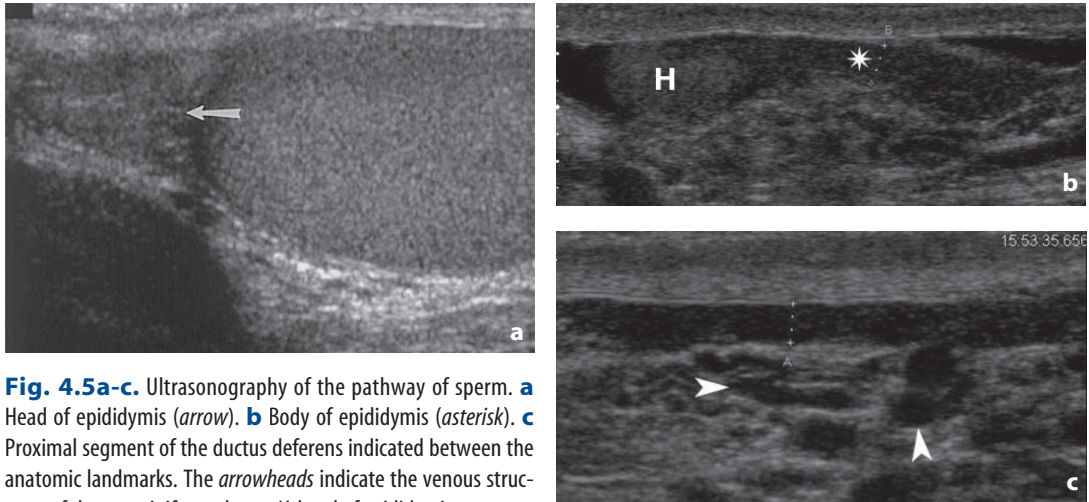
Ultrasonography of the pathway of sperm. a Head of epididymis (*arrow*). b Body of epididymis (*asterisk*). c Proximal segment of the ductus deferens indicated between the anatomic landmarks. The *arrowheads* indicate the venous structures of the pampiniform plexus. *H*, head of epididymis
